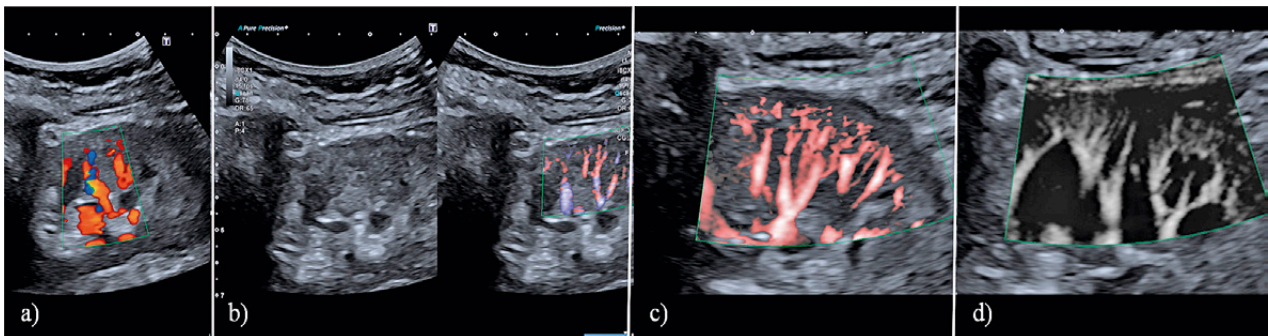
Kidney cortex using different display modes. Color Doppler (a). Advanced Dynamic Flow mode (b). Color SMI (cSMI) (c). Monochrome SMI (mSMI) (d).
